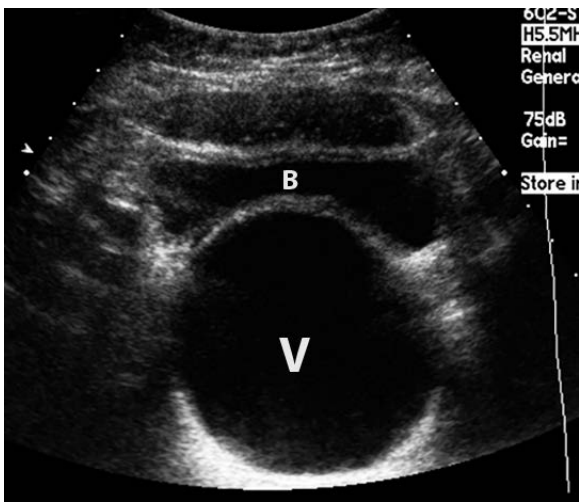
Hematocolpos. Annotated. Pelvis. Ultrasound. Transverse plane. The fluid-filled and distended vagina (V) compresses the anterior bladder (B). A small amount of contained dependent echogenicity in the vagina is consistent with hemorrhagic (versus proteinaceous or infectious) debris.
